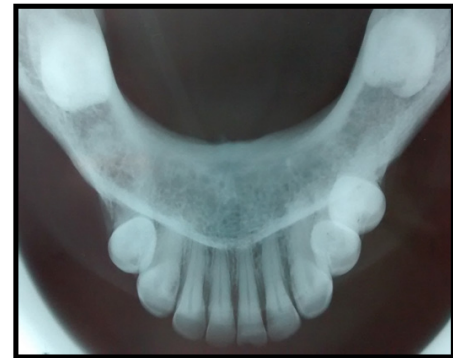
Postop radiograph
